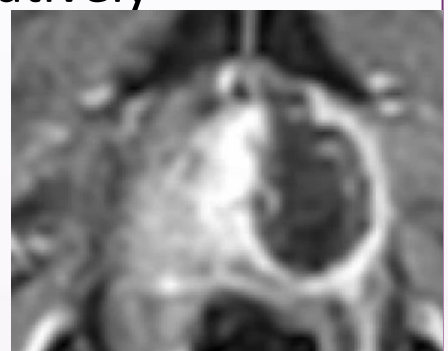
post-cryotherapy MRI
